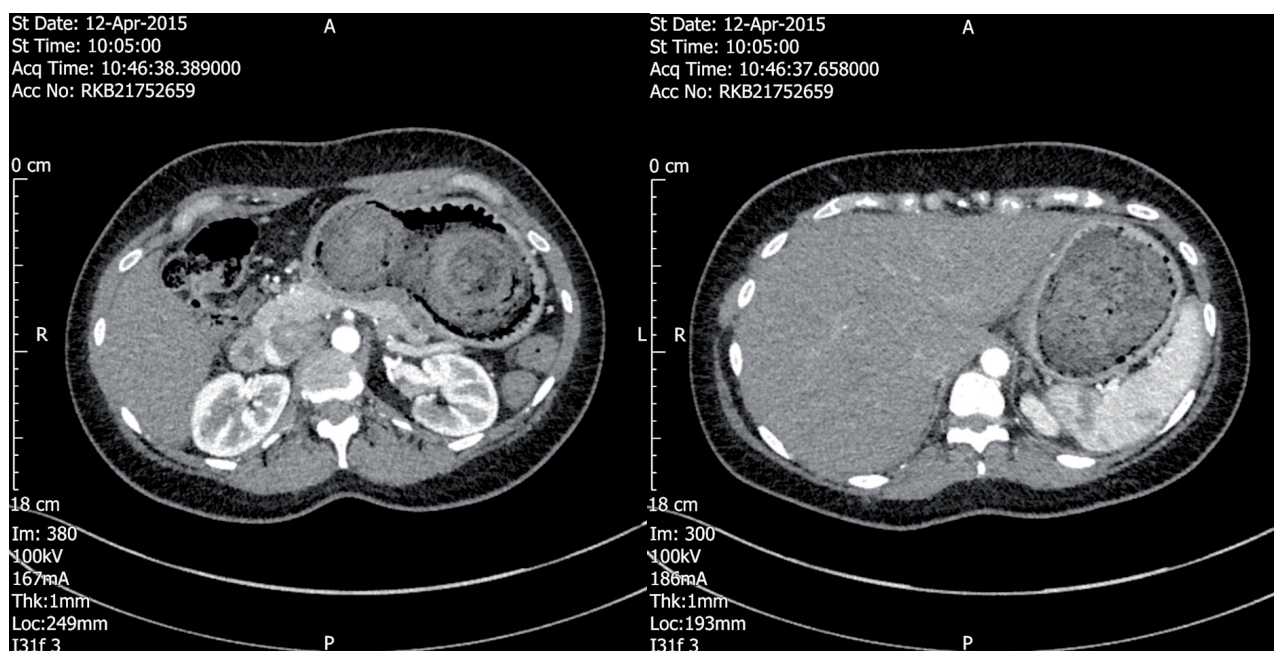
CT scan of the abdomen showing heterogeneously viscous non-enhancing gastric mass suggestive of trichobezoar
